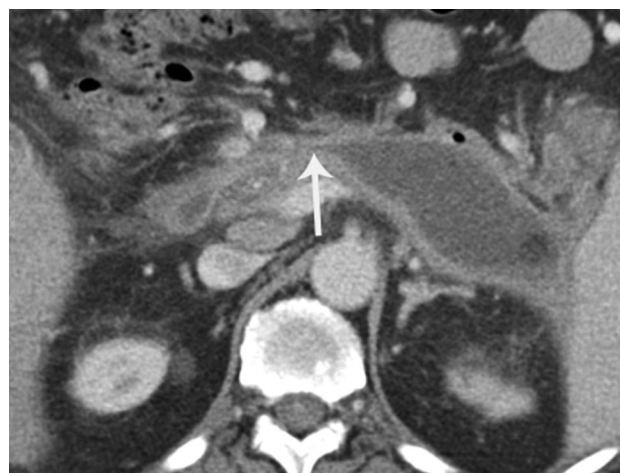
59-year-old man with necrotizing pancreatitis. Axial contrast-enhanced CT image demonstrates a large intra-pancreatic collection (WON) with a communicating main pancreatic duct (*arrow*).
